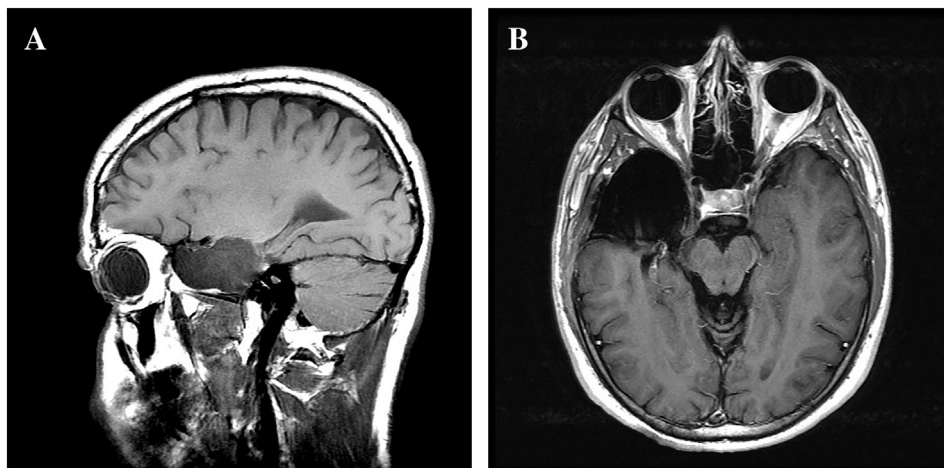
Follow-up MRI at 1-year post-resection. (A) Sagittal T1. (B) Axial T1.
